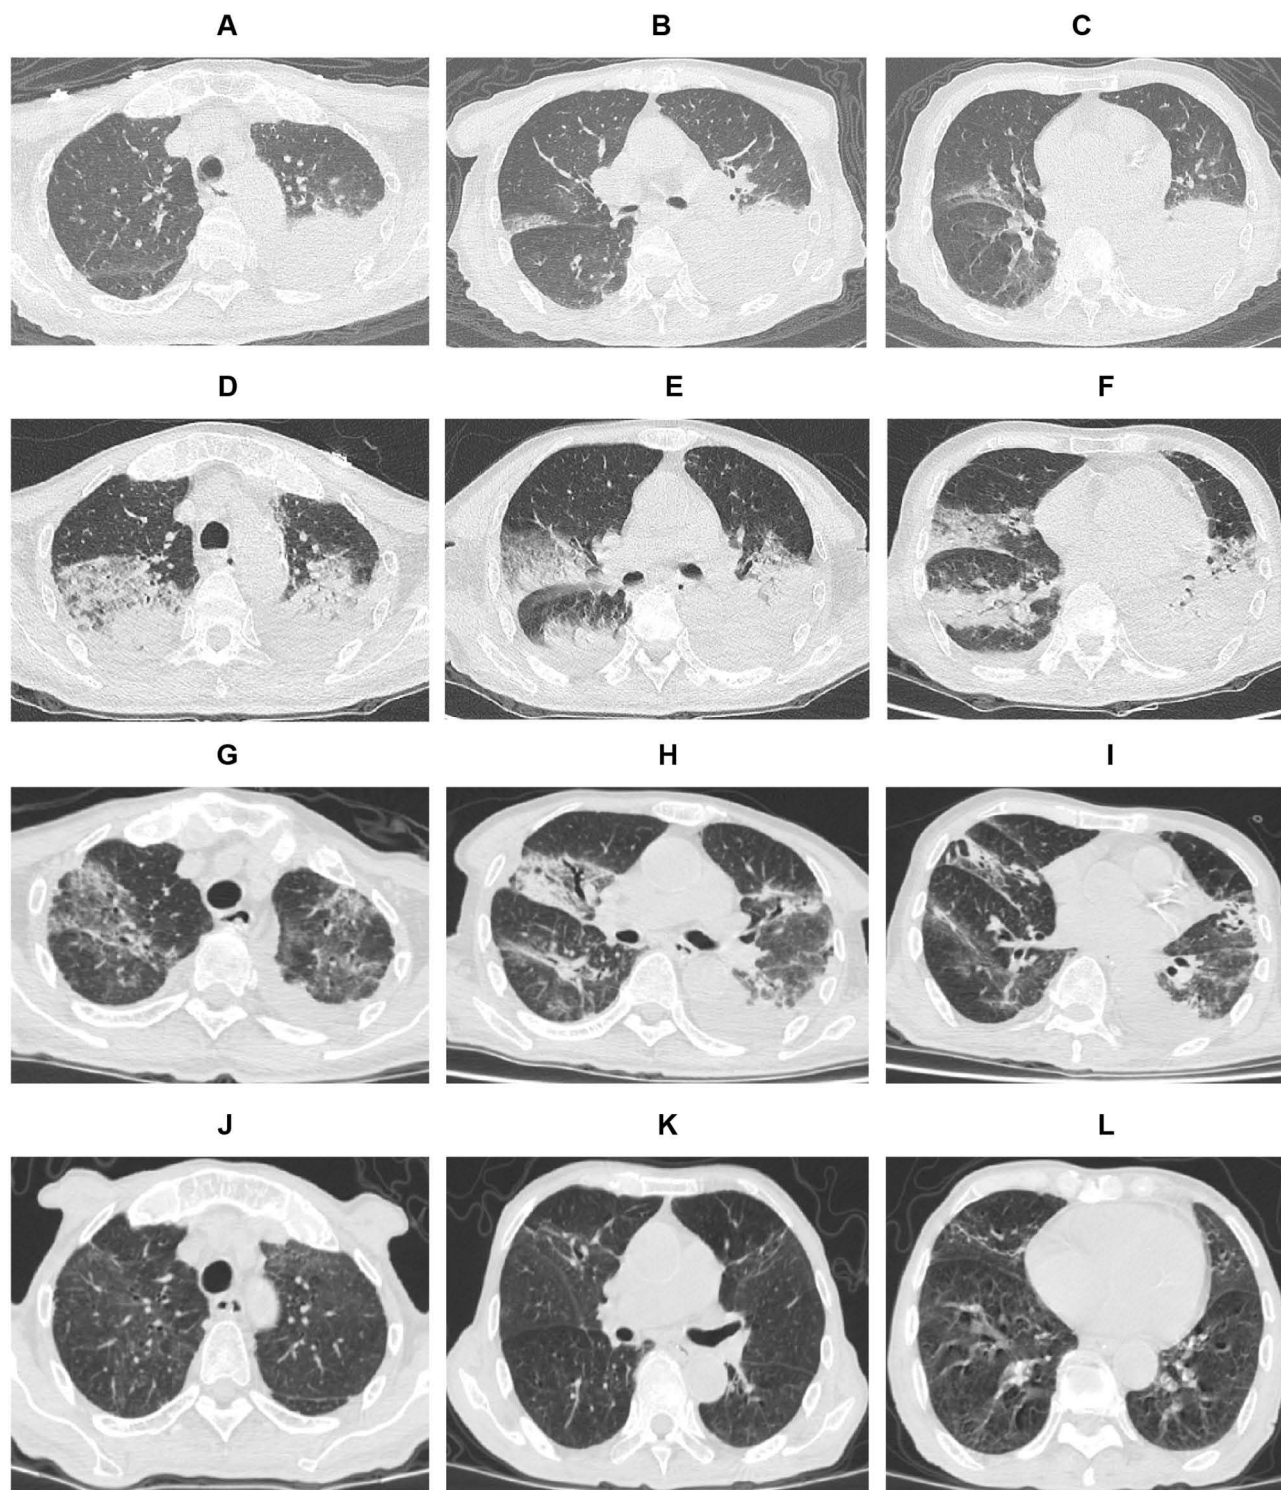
Chest computed tomography (CT) images. (A–C) Chest CT 1 day before admission, showing a large consolidation in the left lung and patchy exudative lesions in the right lung, a small amount of pleural effusion in the left lung. (D–F) Chest CT on hospital day 4, showing bilateral increases in lung lesions. (G–I) Chest CT on hospital day 22, showing marked resolution of bilateral lung lesions. (J–L) Chest CT 2 months after discharge, showing almost complete resolution of the lung lesions, with only a few fibrotic streaks remaining.
